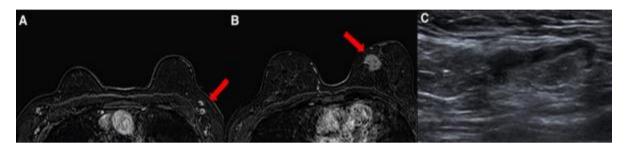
(A) T1 fat-saturated magnetic resonance imaging, (red arrow) showing bilateral enlarged nodes with central fatty hilum (B) Suspicious mass (red arrow) was seen in median-inner quadrant of left breast (C) Ultrasound showed normal appearance of axillary lymph node.
